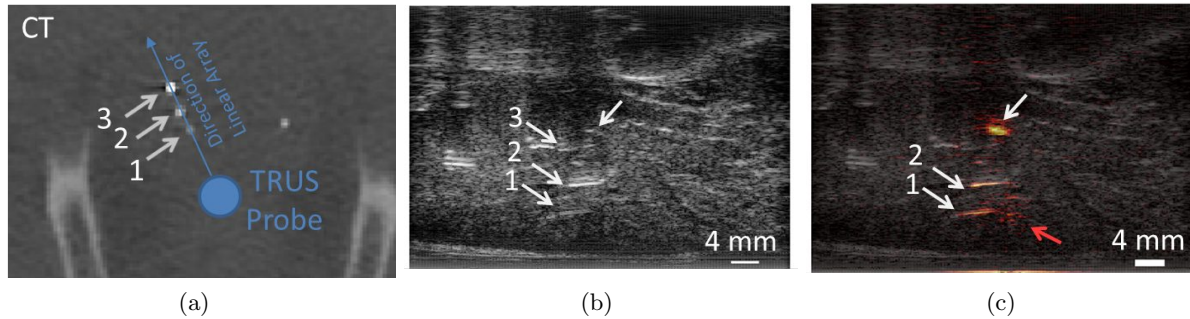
Visualization of multiple coated brachytherapy seeds with (a) post operative CT, (b) conventional ultrasound imaging, and (c) corresponding photoacoustic images overlaid on ultrasound images in a yellow-red color scale. The energy density at the fiber tip for the photoacoustic images was 123 mJ/cm², respectively. Unlabeled arrows point to the photoacoustic response from the location of the fiber (red arrow) and a signal of unknown origin (white arrow).
